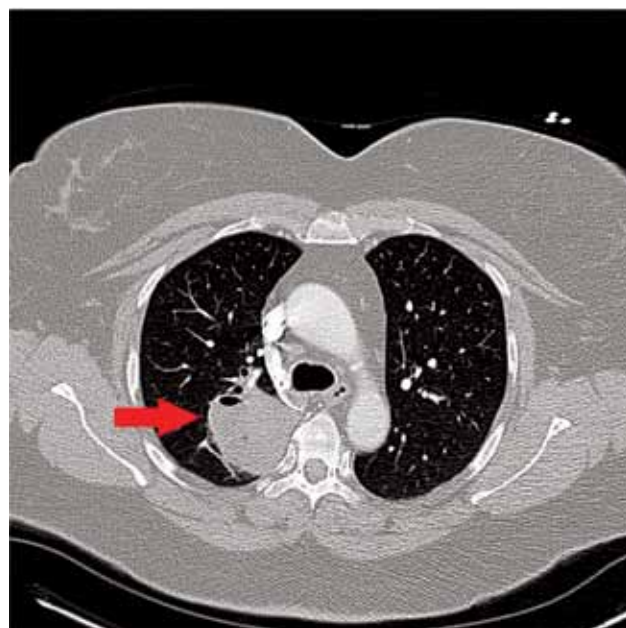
A CT scan of the chest shows a >5 cm mass-like density in the right upper lobe with a focus of gas or cavitation.
